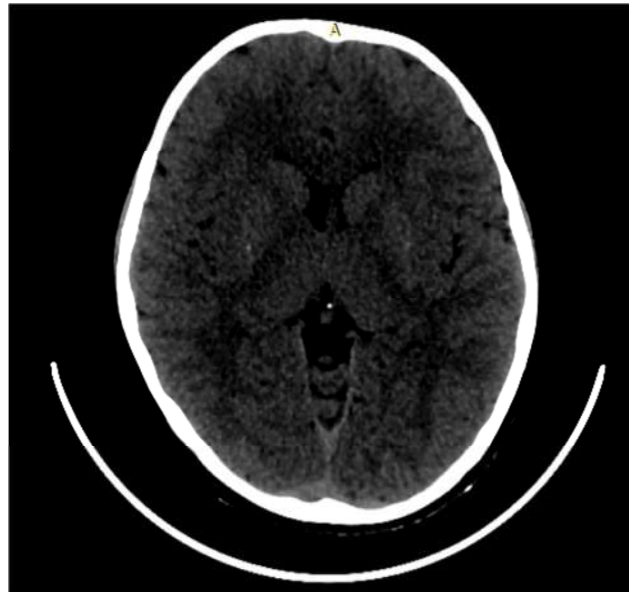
Axial CT image of a 12 year old male child born via vaginal delivery who had history of PROM of 24 hours during peripartum period with mineralizing angiopathy showing linear streak of calcifications along the left lentiform nucleus, the child underwent decompressive craniectomy post basal ganglia infarction post trauma.
